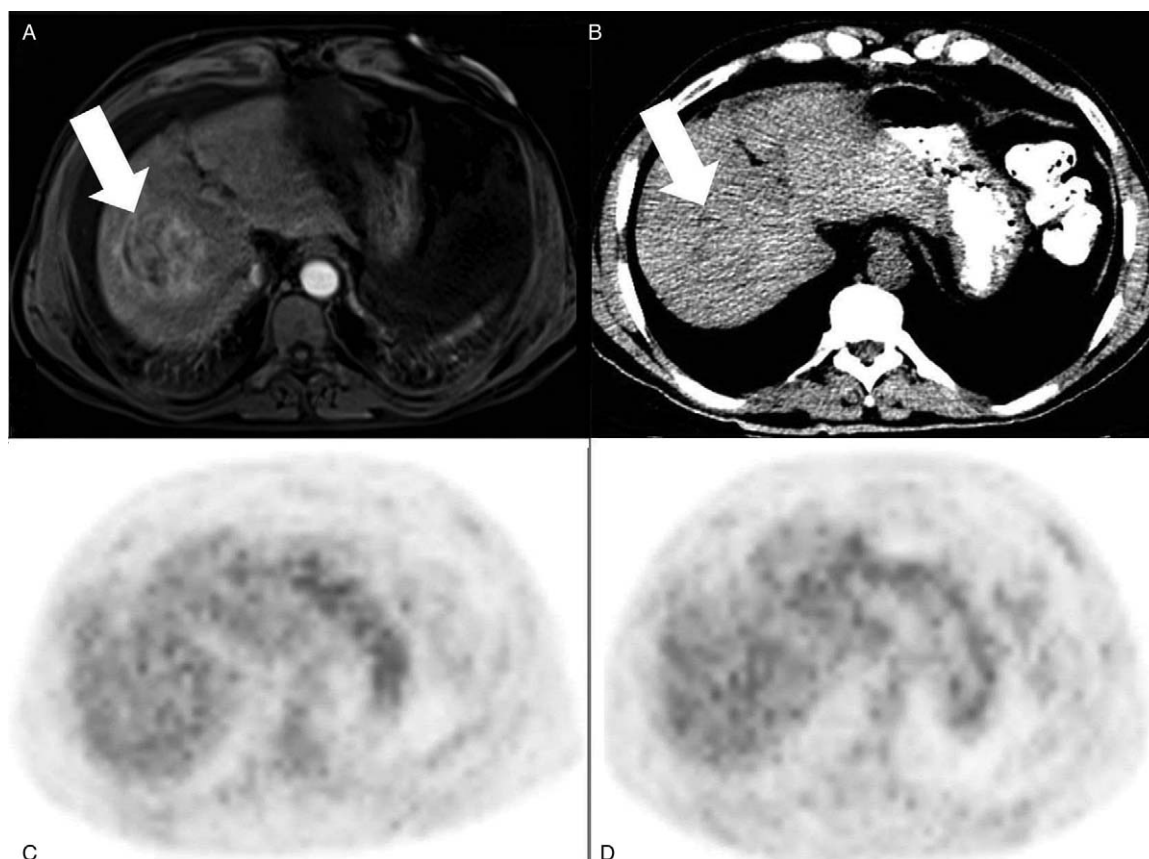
An example of a patient without distinct tumor uptake in which no change can be seen on delayed images. A, Hypervascular mass at the right lobe on magnetic resonance imaging (MRI). B, Hypodense mass on non-contrast-enhanced low-dose computed tomography (CT). C–D, Similar tumor ^{18}F -FDG uptake at both delayed and early ^{18}F -FDG PET/CT images when compared to the liver parenchyma. SUVmax 3.3 and 3.0 for early and delayed images, respectively.
